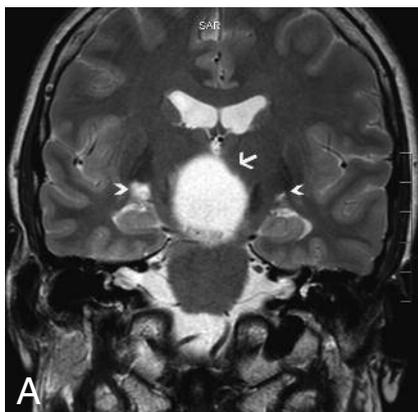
Patient 1. A. Coronal T2-weighted image (TR: 3000 ms, TE: 80 ms). Notice the mainly cystic suprasellar mass (arrow). There is definite edema of both optic tracts (arrowheads). B. Axial FLAIR image (TR: 9000 ms, TE: 114 ms, TI: 2500 ms). Notice the suprasellar mass (arrows), with a discrete fluid-fluid level (curved arrow). There is edema of both optic tracts (arrowheads).
